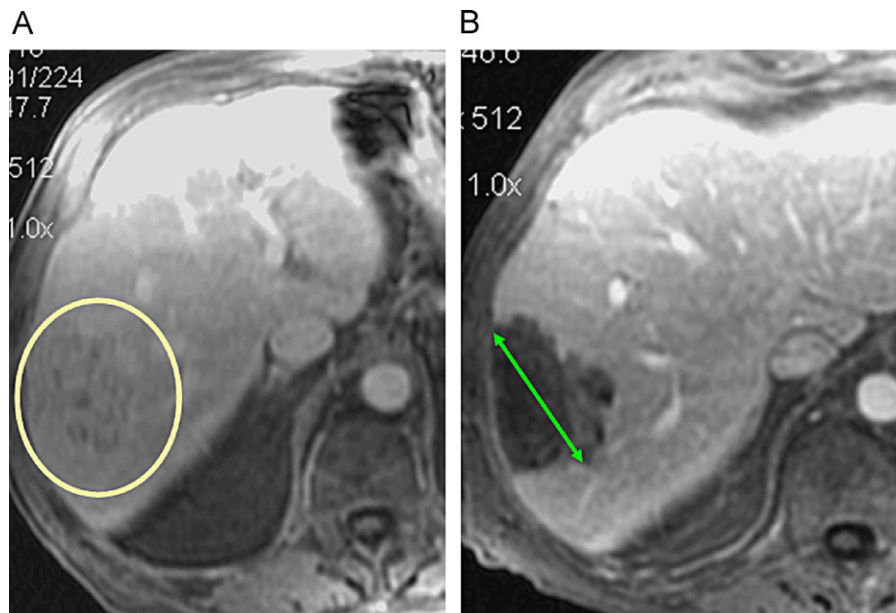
(A) Pretreatment MRI T1 post-gadolinium imaging showing tumor with heterogeneous enhancement before TACE (circle). (B) Following TACE there was complete lack of enhancement, consistent with necrosis and response (double-headed arrows indicate tumor diameter). (Images courtesy of Jean-Francois Geschwind, Department of Radiology, Johns Hopkins Hospital, Baltimore, MD.)
